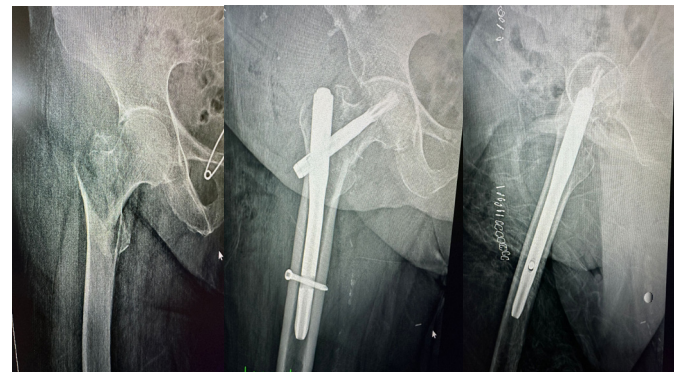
Preoperative radiographs of a 84-year-old female patient who underwent PFN due to pertrochanteric femur fractures (A); postoperative posterior-anterior (B1) and lateral radiographs (B2)
